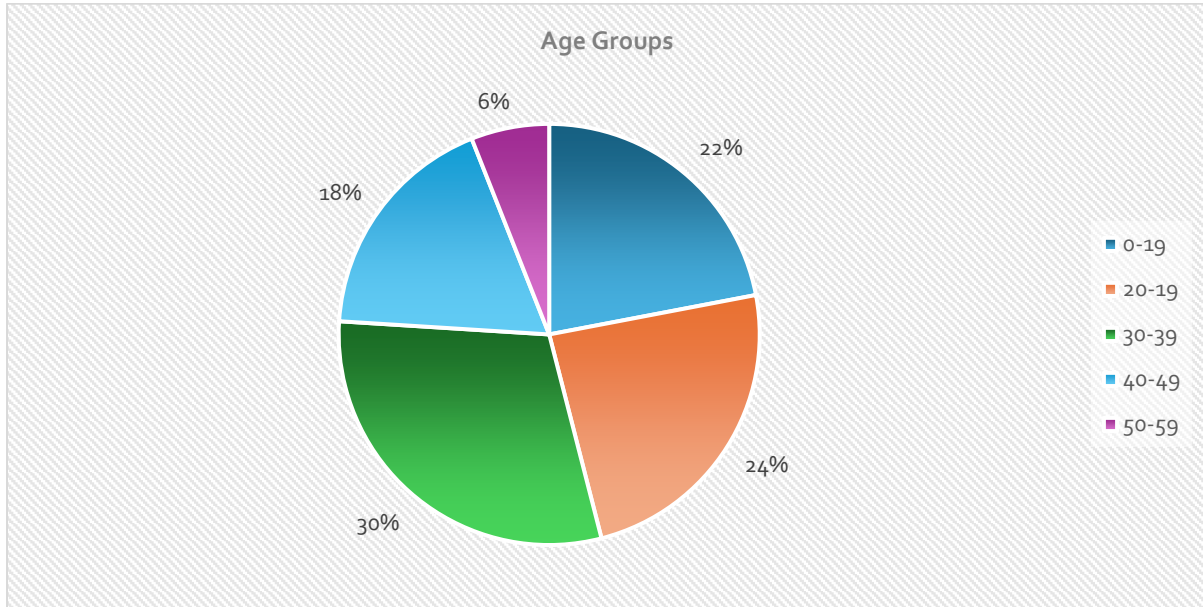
TIF MRI patient survey: patients' age distribution
